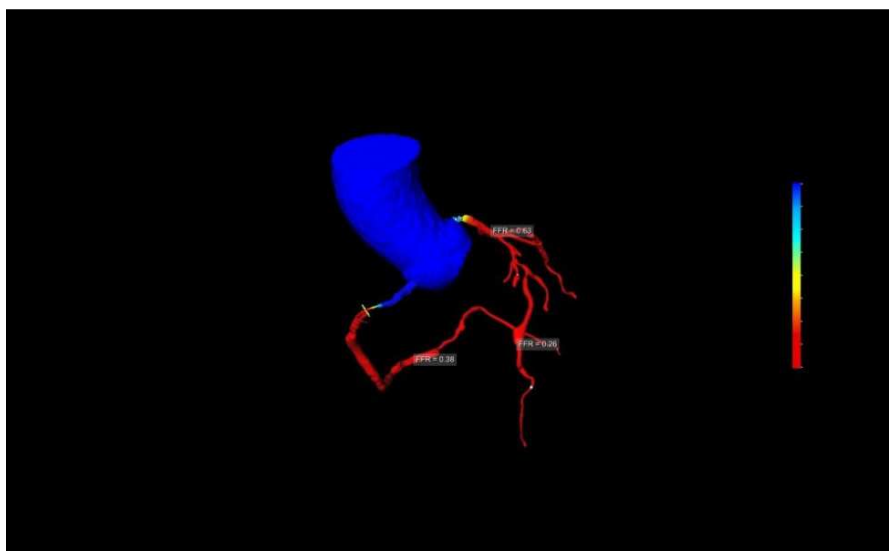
Steps of centre line extraction, luminal tracing by AI method with CT FFR.
